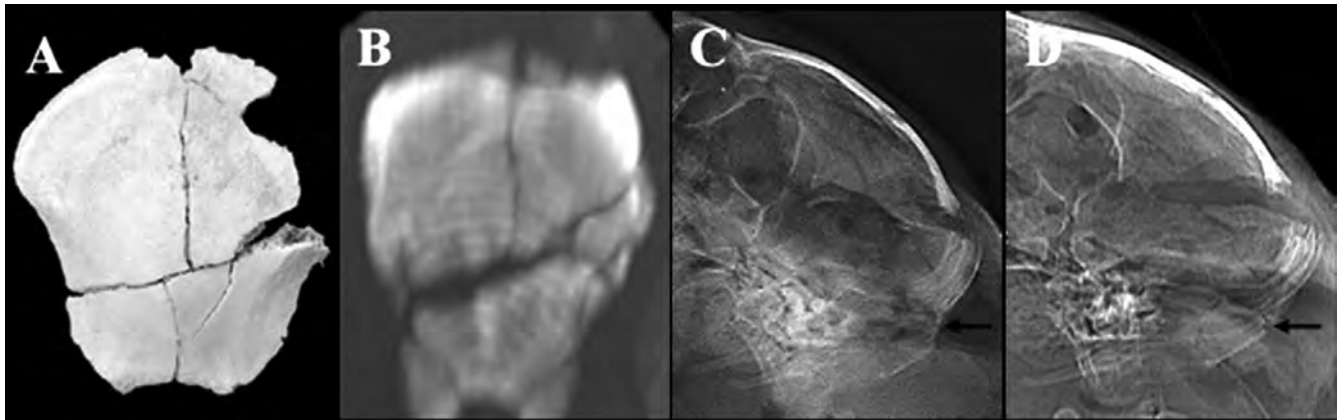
Complex occipital fracture as seen on dry bone (A) and CT (B) but classified as simple linear (solid black arrow) on X-ray (C) and Lodox® (D) on all radiographic views
